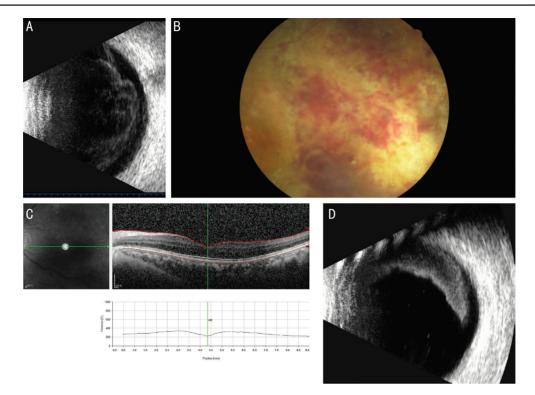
Photos of PCNSL with intraocular involvement A: Clusters of moderately or highly condensed punctate echoes were observed in the B-scan ultrasound examination of the eyes; B: Yellow deposits in the retina were observed; C: Normal central foveal thickness was detected through OCT scanning; D: Suspected eccentric masses were observed on ultrasound but not on slit lamp examination.
